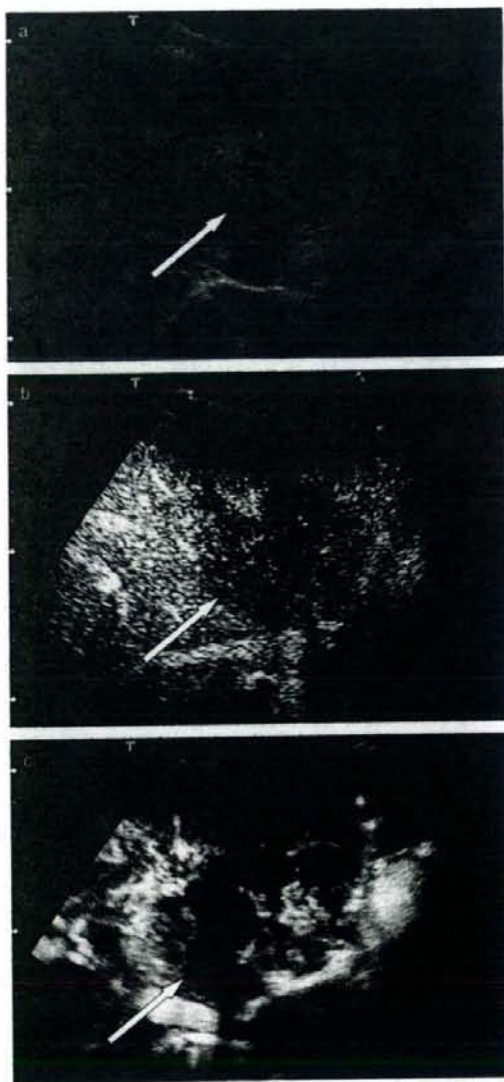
A 69-year-old woman with a 50-mm-diameter, poorly-differentiated hepatocellular carcinoma (HCC) in the left lobe of her liver. (a) Baseline ultrasound image shows a HCC (arrow) with mosaic pattern appearance in the left hepatic lobe. (b) Conventional harmonic image obtained during the portal venous phase—that is, 48 s after injection of the microbubble contrast agent—shows HCC (arrow) with heterogeneous enhancement. An avascular area, which is believed to be a necrotic region, is also noted in the tumor. (c) Microflow image obtained during the portal venous phase—that is, 53 s after injection of the microbubble contrast agent—shows tumoral blood vessels clearly. However, they are sparser than in moderately-differentiated HCC. Tapering and interruption of the vessels may be noted. Properties are characteristic of the dead wood pattern.
